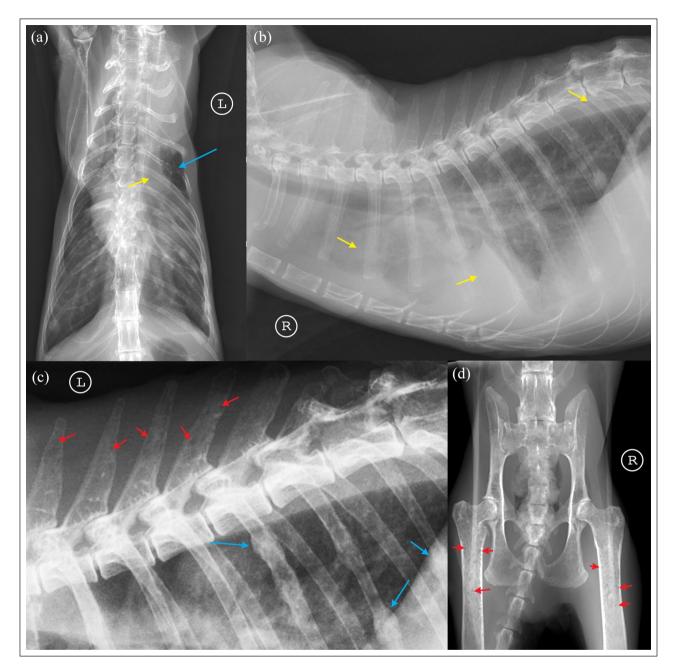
(a) Thoracic ventrodorsal projection radiograph. A pathological fracture of the fifth rib (blue arrow) and pleural effusion are seen (yellow arrow). (b) Right thoracic lateral projection radiograph. Pleural effusion is present (yellow arrows). (c) Left lateral projection radiograph of thoracic spine: numerous circular bone lytic lesions are observed on spinous processes (red arrows) and probably healed rib fractures (blue arrows). (d) Ventrodorsal projection radiograph of the pelvis: osteolytic lesions are observed, involving proximal extremities of both femurs (red arrows)
